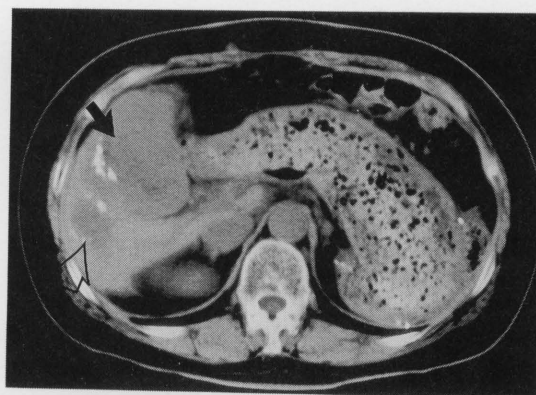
CT scan shows a huge tumor (arrow) and another small tumor (open arrow) lying close to it.
